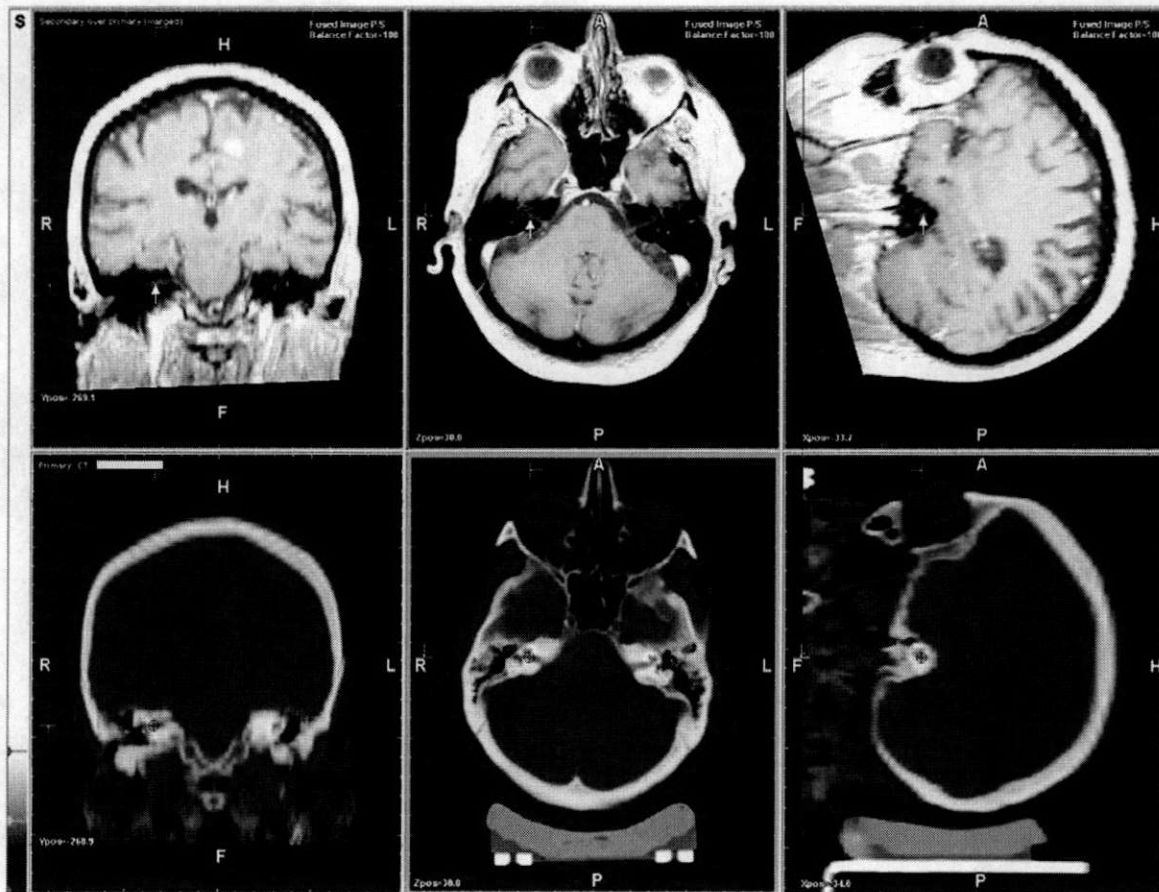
Registered magnetic resonance (top row) and computed tomography (bottom row) brain scans. Coronal and sagittal reformats are left and right of the original transaxial scans. The cursor [circled cross (and arrow on MR)] is towards the distal end of the right vestibulocochlear nerve, an example of a suitable landmark (well localised in three-dimensions) for image registration verification.
